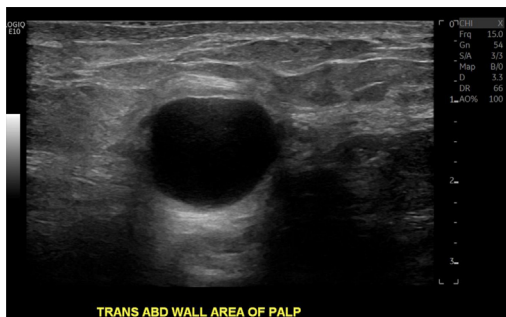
Transabdominal ultrasonography with hypoechoic nodule in the cesarean delivery scar. Final pathology demonstrated abdominal wall endometriosis (AWE).
